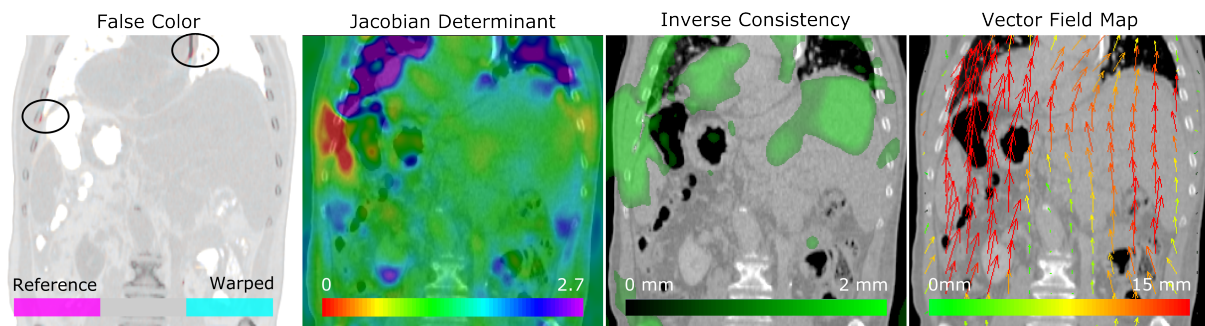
Coronal view of the DIR quality assessment between a 0%Ex and a 100%Ex state CT. The *False Color* image corresponds to the overlay between the (reference) 0%Ex CT and the transformed 100%Ex CT (i.e warped image), in which two regions with observable differences are highlighted by the black circle. The values of the JD and ICE can also be overlaid in the patient CT, and be used to identify regions in which the vector field can have inconsistencies. Finally, the displayed vector field map is also shown, in which the direction and length quantifies of the transformation between images is represented by each arrow.
